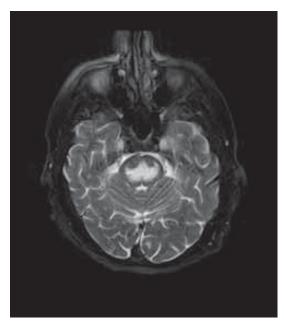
(Above): Freddy's MRI on presentation at Westmead Hospital.
